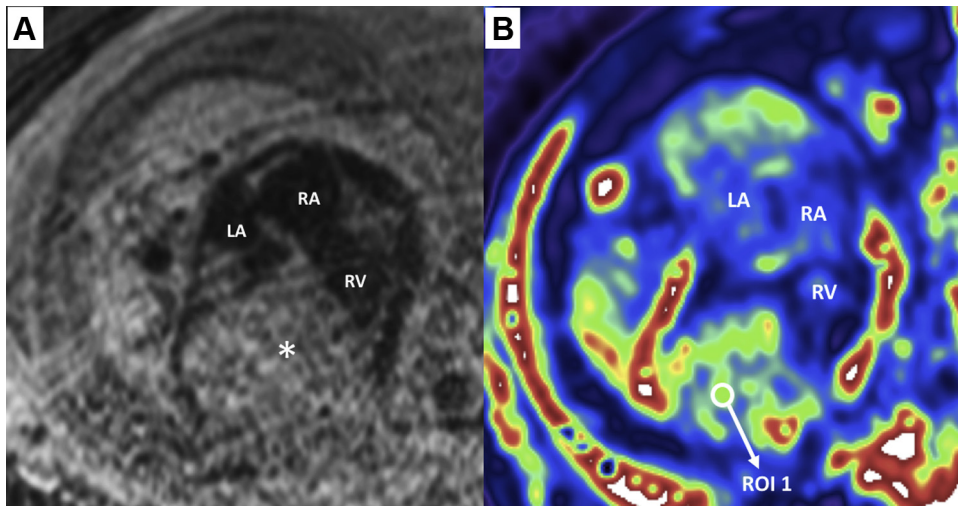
Fetal Cardiac MRI at 29 Weeks Gestation
